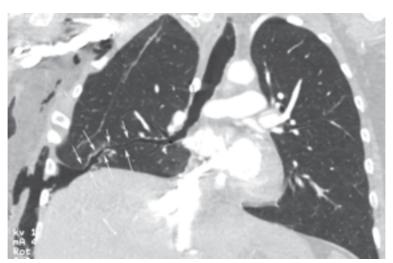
Curved coronal CT reconstruction showing a bronchopleural fistula in the anterior segment of the right lower lobe.
